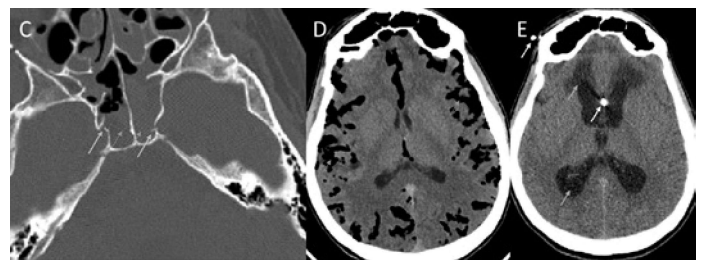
CT bone window, the yellow and red arrows shows the fractures of the walls of the sphenoid cavity with blood and CSF inside. D,E image. The blue arrow marks extensive pneumocephalus and the gray arrow at follow up images shows the developing communicating hydrocephalus which was treated with ventriculoperitoneal shunting- white arrows [2]
